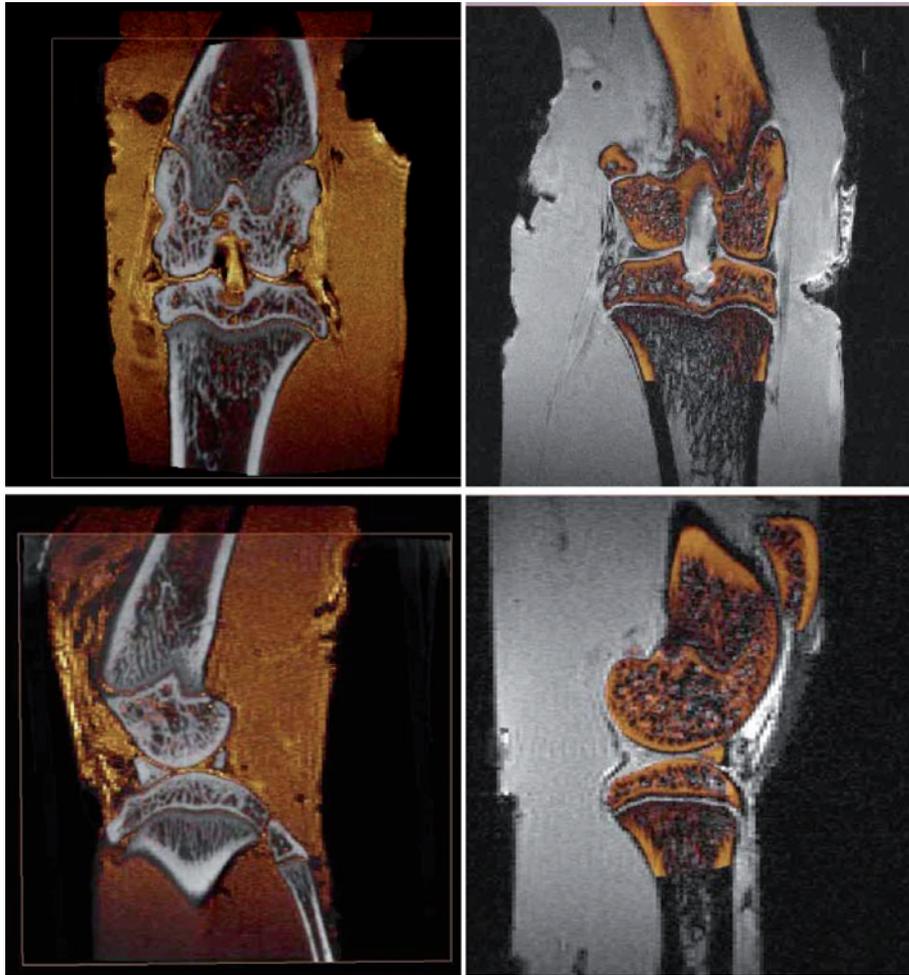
Registration of μ MRI and μ CT datasets from Fig. 14. In the two images on the left the μ CT part is gray and the μ MRI part is colored; in the two images on the right the color coding is inverted. (See plate section)
